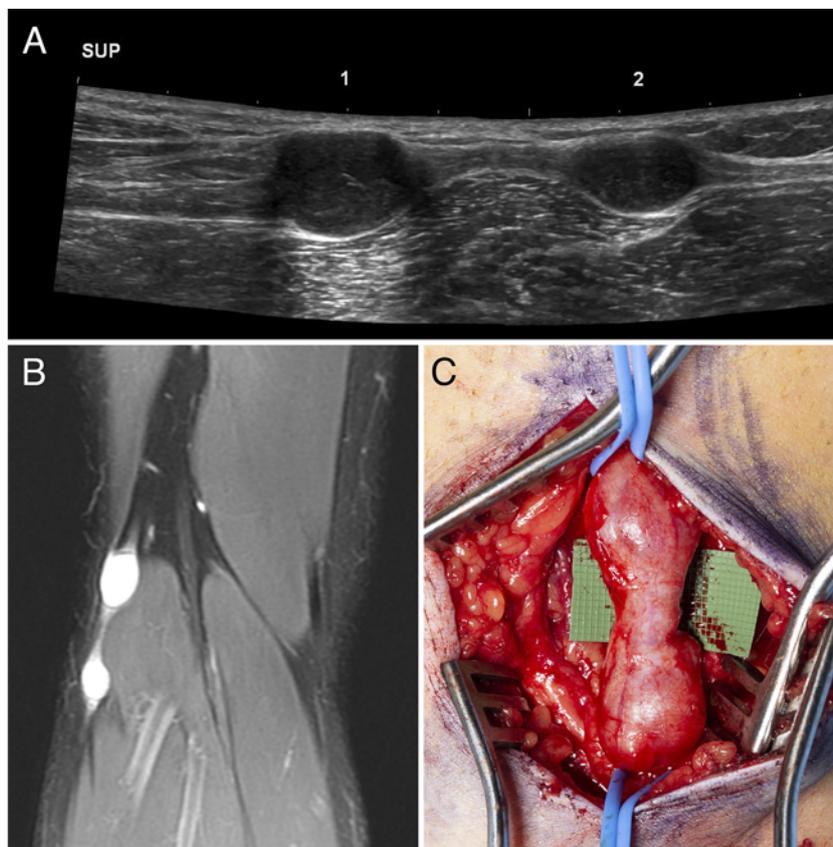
Example of a case of schwannomatosis with 2 schwannomas in the CPN. A: Preoperative ultrasound images showing 2 hypoechoic lesions in the course of the CPN. B: Coronal T1-weighted Gd-enhanced MR image demonstrating the same lesions in the CPN. C: Intraoperative photograph of the 2 lesions in the CPN that were resected during the same surgery.
